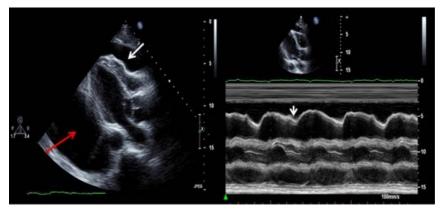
Two-dimensional echocardiogram shows a moderate anterior PEff (*white arrow*) and large pleural effusion (*red arrow*) (Video 3; available at www.onlinejase.com). There is early RV diastolic collapse combined with tamponade physiology, as noted on M-mode (*white arrowhead*).
